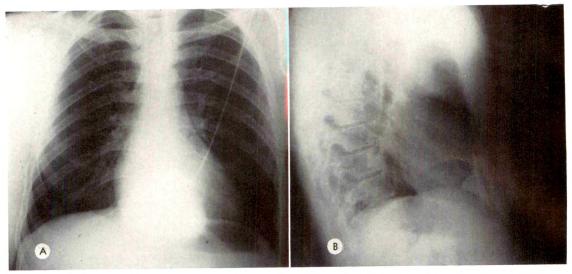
Patient stabbed just above the diaphragm with an ice pick. Injection of contrast material demonstrated in the (A) anteroposterior and (B) lateral roentgenograms that neither the peritoneum nor the pleural spaces were entered. The hypaque is confined to the anterior mediastinum.
